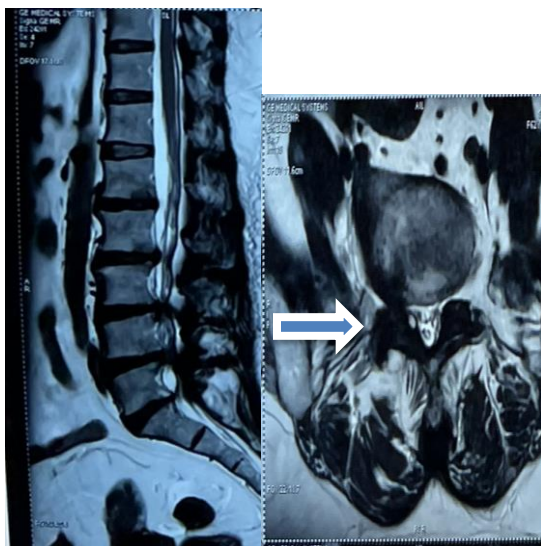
The sagittal T2 weighted shows posterior protruding disc of lumbosacral spines, and degenerative disc disease. The axial T2 weighted lumbar MRI showing narrowing of spinal canal at L2/L3, L3/L4, L4/L5, with facet joint hypertrophy, and thickening of ligamentum flavum at L3/L4, and L4/L5 bilaterally.
